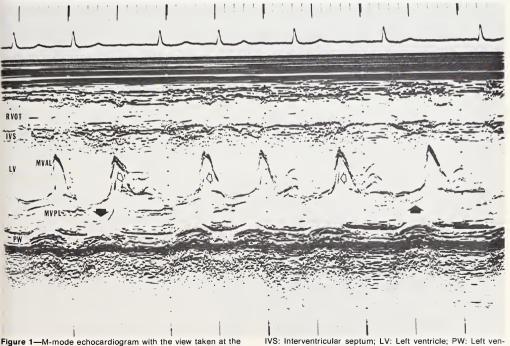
M-mode echocardiogram with the view taken at the level of the mitral valve. The posterior mitral leaflet reveals systolic prolapse (closed arrows) and paradoxical diastolic motion (open arrows). RVOT: Right ventricular outflow tract;
